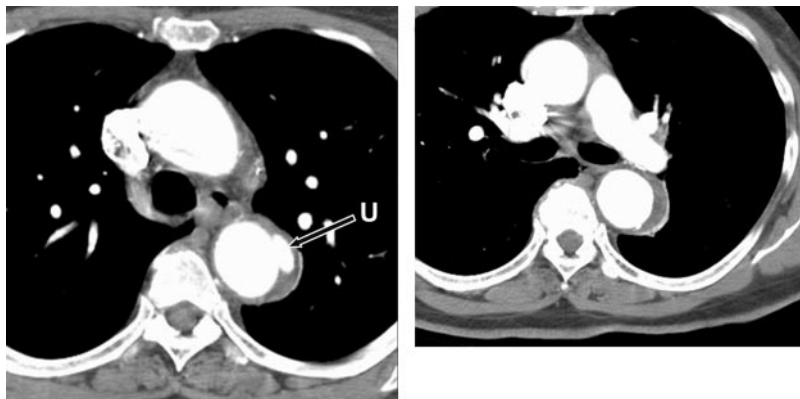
Penetrating atherosclerotic ulcer of the proximal descending thoracic aorta. Axial CT images at the level of the aortopulmonary window (left) and at the level of the left pulmonary artery (right) demonstrate a small penetrating ulcer (long arrow, U) that extends beyond the expected confines of the aortic lumen with adjacent IMH both at the level of the ulcer itself and that extends a few centimeters caudally in the wall of the descending thoracic aorta (short arrows). CT indicates computed tomographic imaging; IMH, intramural hematoma; and U, penetrating ulcer.
